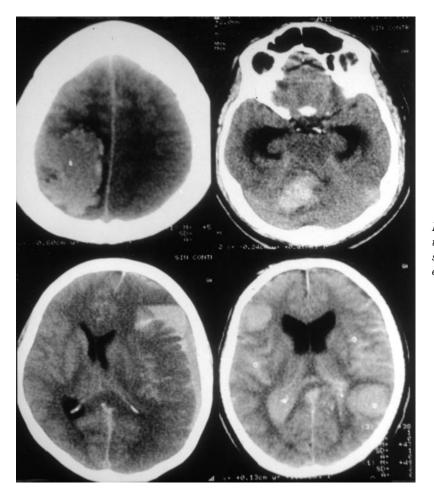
CT showing different patterns of intracranial hemorrhages related to Bothrops spp. envenoming. Note the low attenuation coefficient of the bleeding due to severe anemia.
